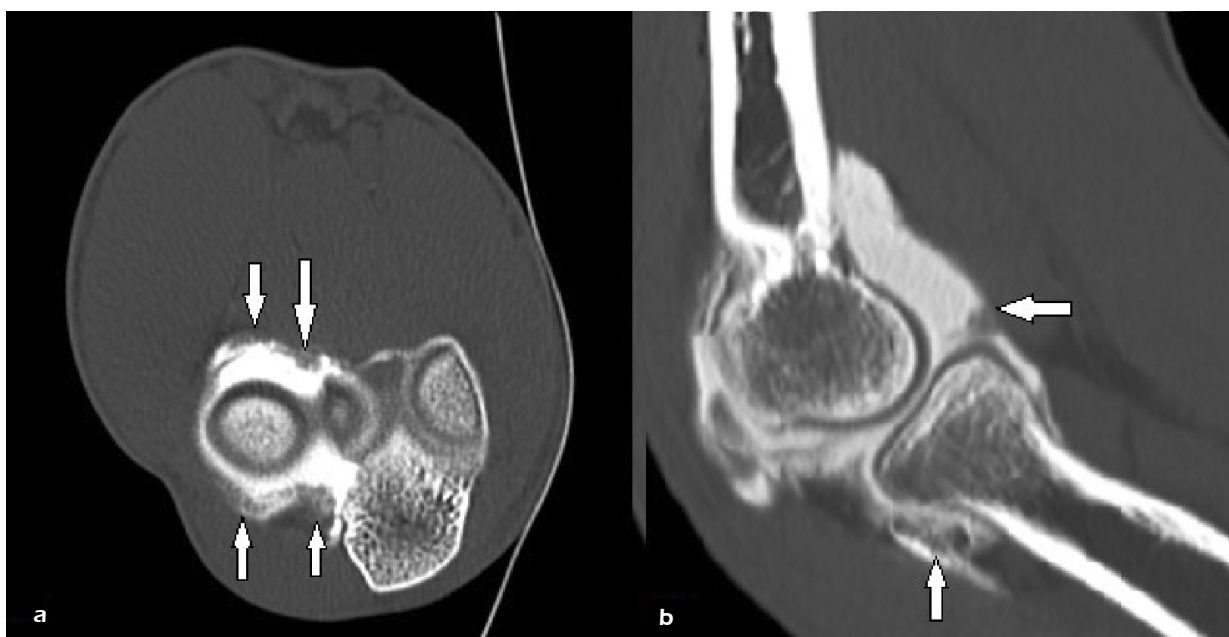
Axial (a) and sagittal (b) CT-arthrography images showing a synovial thickening at the anterior and posterior aspect of the radial head (white arrows).
